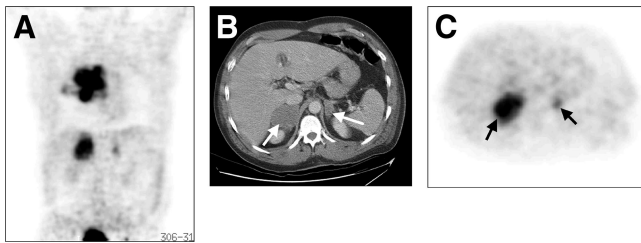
(A) ^{18}F -FDG PET scan shows intense uptake in right adrenal mass and uptake slightly higher than that of liver in left adrenal mass. (B) CT scan shows bilateral adrenal masses; right adrenal lesion is larger than left (arrows). (C) ^{18}F -FDG PET axial view at same level as for CT shows intense uptake in right adrenal mass and uptake slightly higher than that of liver in left adrenal mass (arrows).
